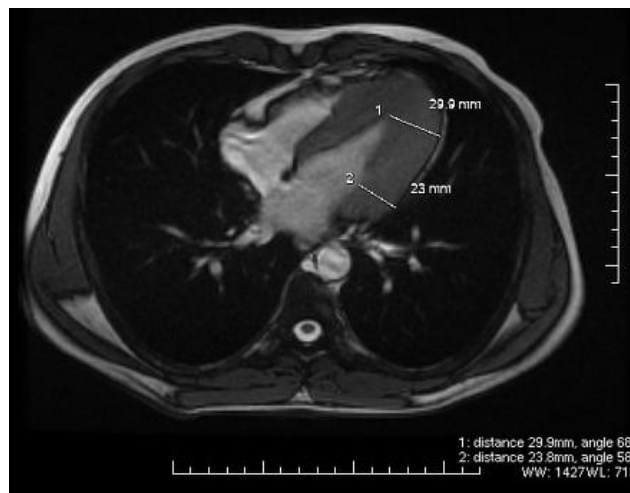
MRI for Hypertrophic Cardiomyopathy [21]
